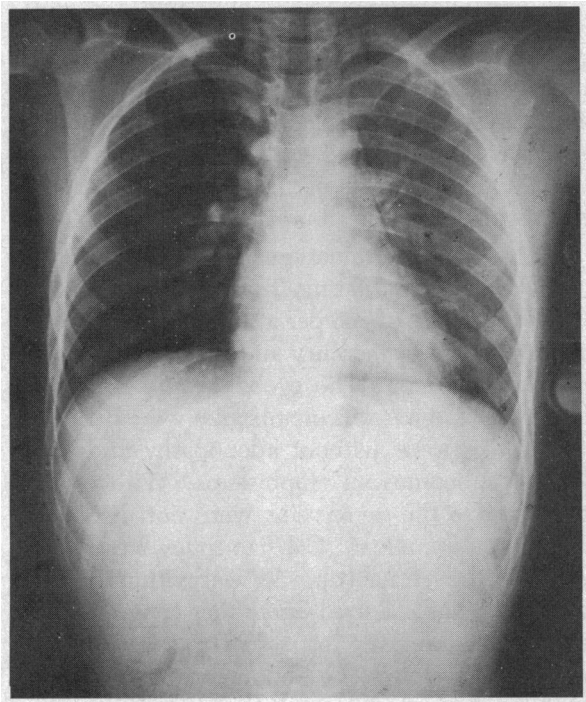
X-ray film taken shortly after admission shows air in the mediastinum and pericardial sac.
